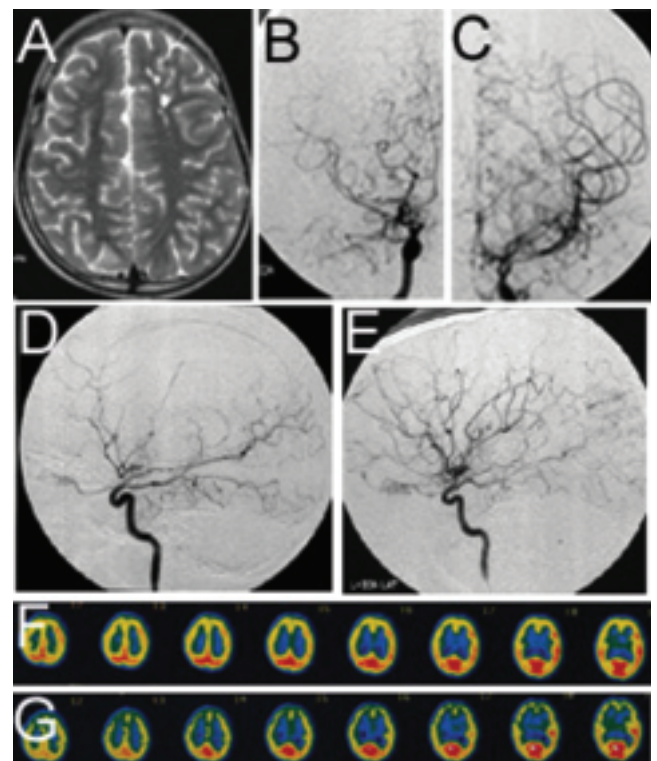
A: A magnetic resonance image obtained in November 2001 demonstrating an ischemic lesion at the left frontal lobe. B–E: Angiograms (right anteroposterior view) obtained in November 2001 showing stenocclusive changes at the terminal portions of the bilateral ICAs and the presence of moyamoya vessels at the base of the brain (anteroposterior views of the right [B] and left [C] ICA and lateral views of the right [D] and left [E] ICA). F: A  $^{99m}\text{Tc}$ -ECD SPECT study from January 2002 demonstrating decreased rCBF in the bilateral frontal lobes and reduced rCVR revealed by acetazolamide challenging in the same region (G).
